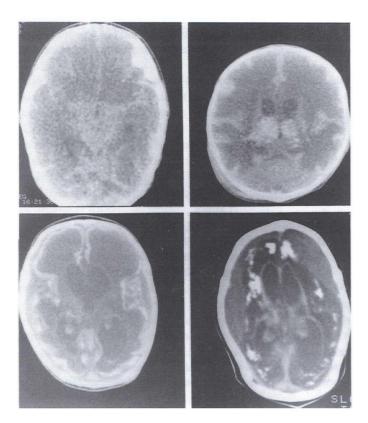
Computed tomography scans of patient 1. Day 2 (upper left) reveals diffuse edema. Day 12 (upper right) demonstrates less edema with reappearance of the lateral ventricles. On day 25 (lower left), generalized atrophy and early calcification appear. At three months (lower right), severe atrophy, calcification, and bilateral subdural collections are seen.
